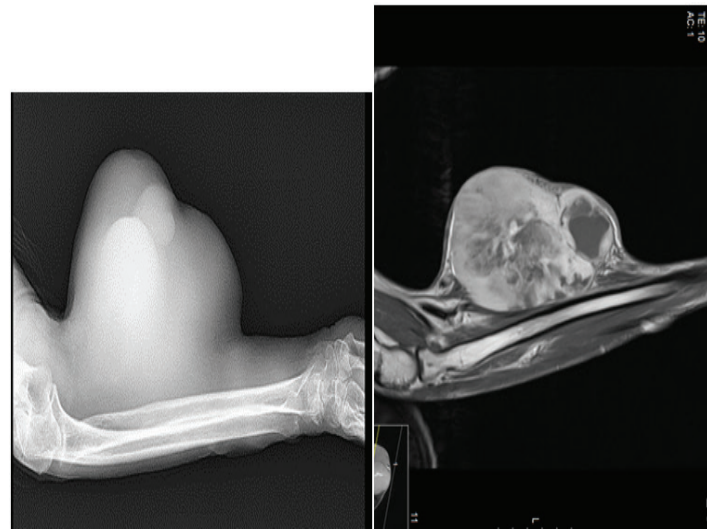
Direct graphy and MRI images of a 56-year old patient who presented with a forearm fibrosarcoma
